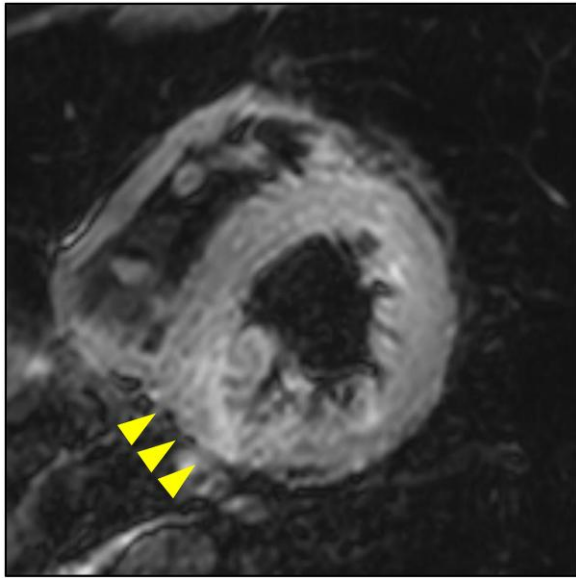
Contrast-enhanced cardiac magnetic resonance imaging. Short-axis images at the papillary muscle level in T2-weighted show diffuse high signal intensity in the left ventricular myocardium, specifically in the basal inferior wall (arrowheads). Late gadolinium enhancement image is omitted due to low image quality.
